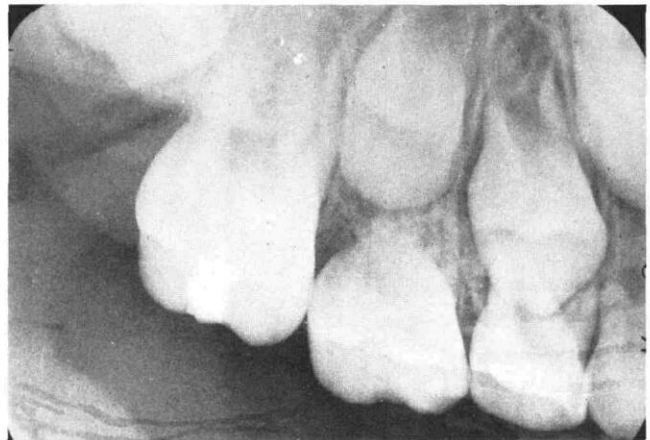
Radiograph of the corrected condition.
